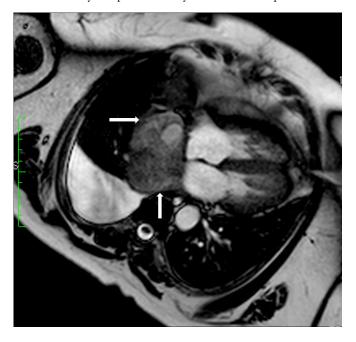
Postoperative cardiac MRI of the patient showing a posterior mediastinal mass (arrows) with no signs of residual intracardiac tumor.
